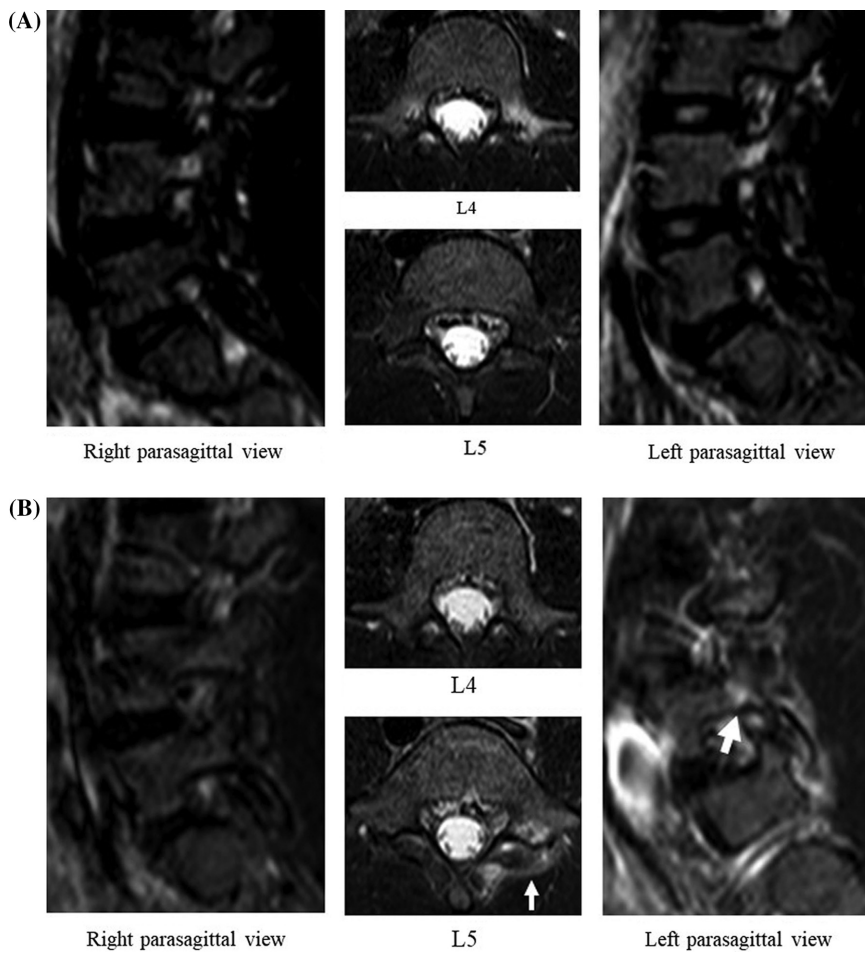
(A) Magnetic resonance images obtained at follow-up 5 weeks later showing a decrease in the high intensity changes at the L4 pedicles bilaterally. (B) Magnetic resonance scans acquired 10 weeks later showing a new high intensity change at the L5 pedicle on the left. The arrows indicate extraosseous and bone marrow edema.
